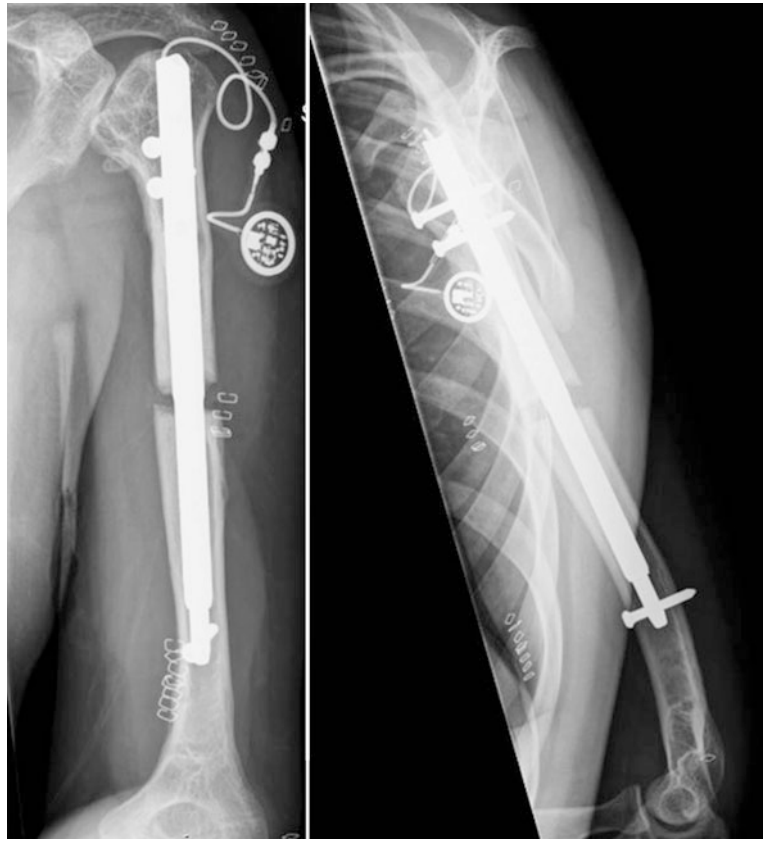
Frontal (*left*) and lateral (*right*) X-rays taken 9 months postoperative showing healing of the bone regenerate. Note the proximal migration of the humeral head
